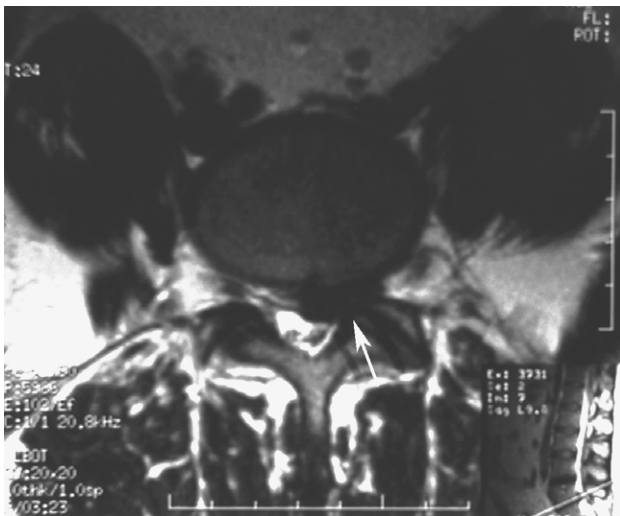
T1-weighted axial lumbar spine MRI showing far lateral disc herniation at L5-S1 (marked area).
